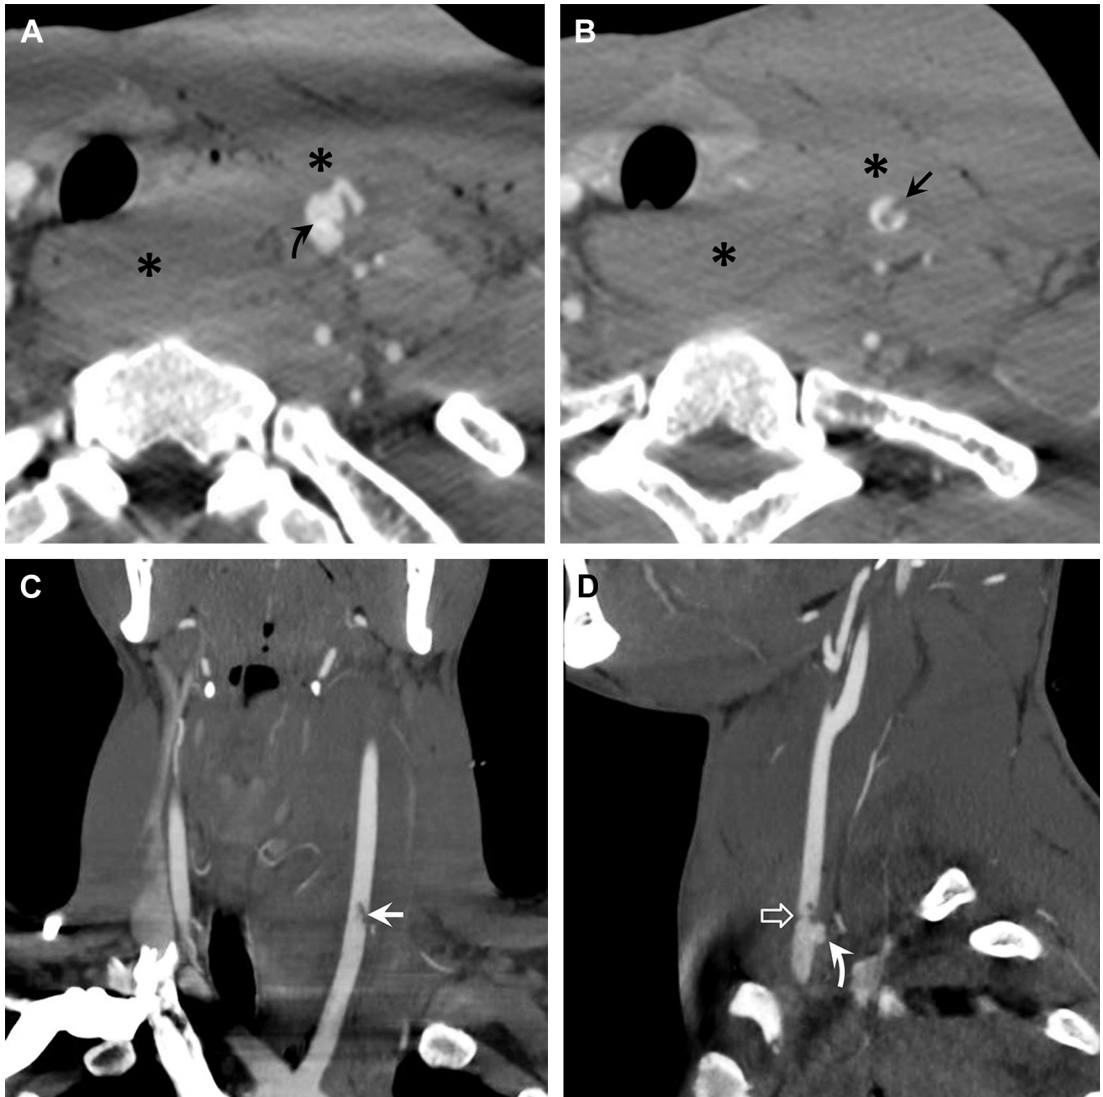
Incomplete left common carotid artery transection. (A, B) Axial CTA images demonstrate extensive retrotracheal and carotid space hematoma (asterisks) with traumatic disruption of the left common carotid artery and a large pseudoaneurysm (curved black arrow). A large intraluminal dissection flap (black arrow) is also present. (C) Coronal and (D) sagittal 2D reconstructed CTA images confirm near complete vessel transection (open arrow), pseudoaneurysm formation (curved white arrow), and a large intimal flap (white arrow).
